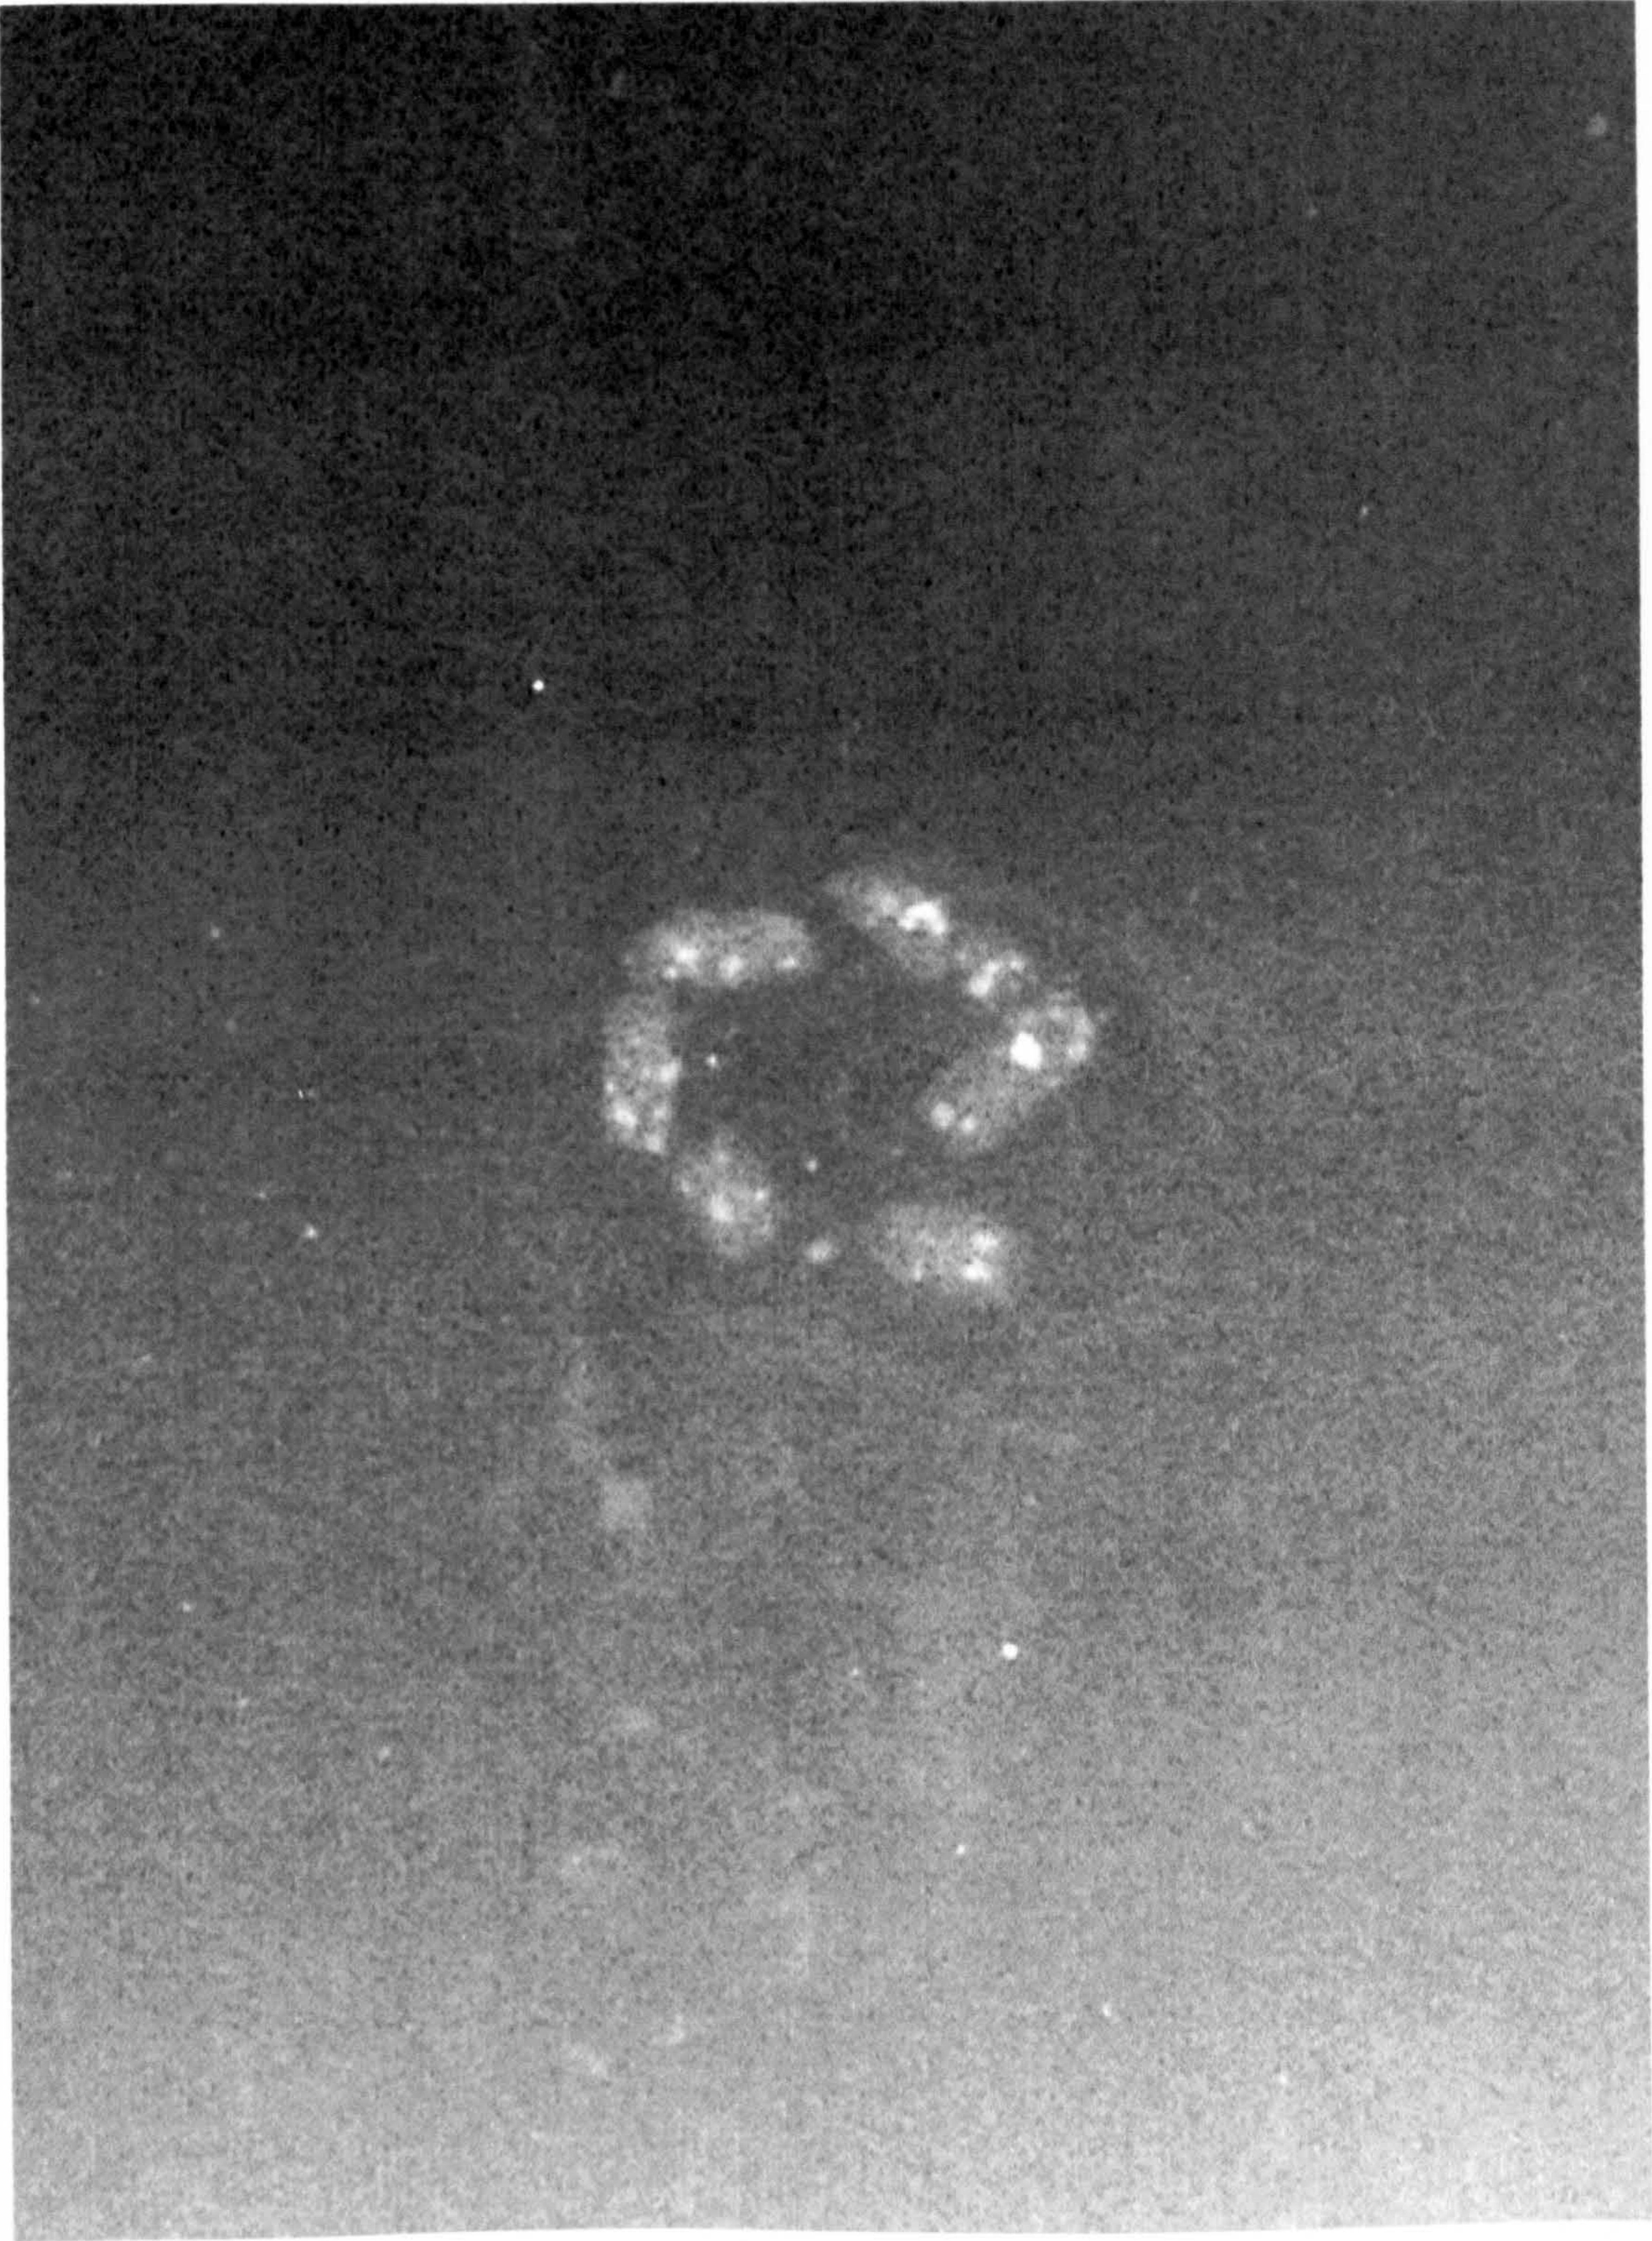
In situ X-ray of pelleted food passing from the stomach whilst still intact.
